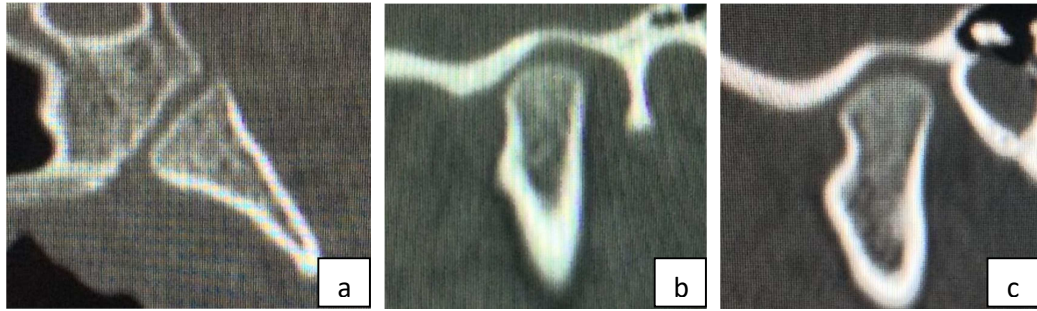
CT images of a 10-year-old boy revealing a) Stage 0 of Spheno-occipital synchondrosis; b) Type I Condylar cortication on right side; c) Type I Condylar cortication on left side
